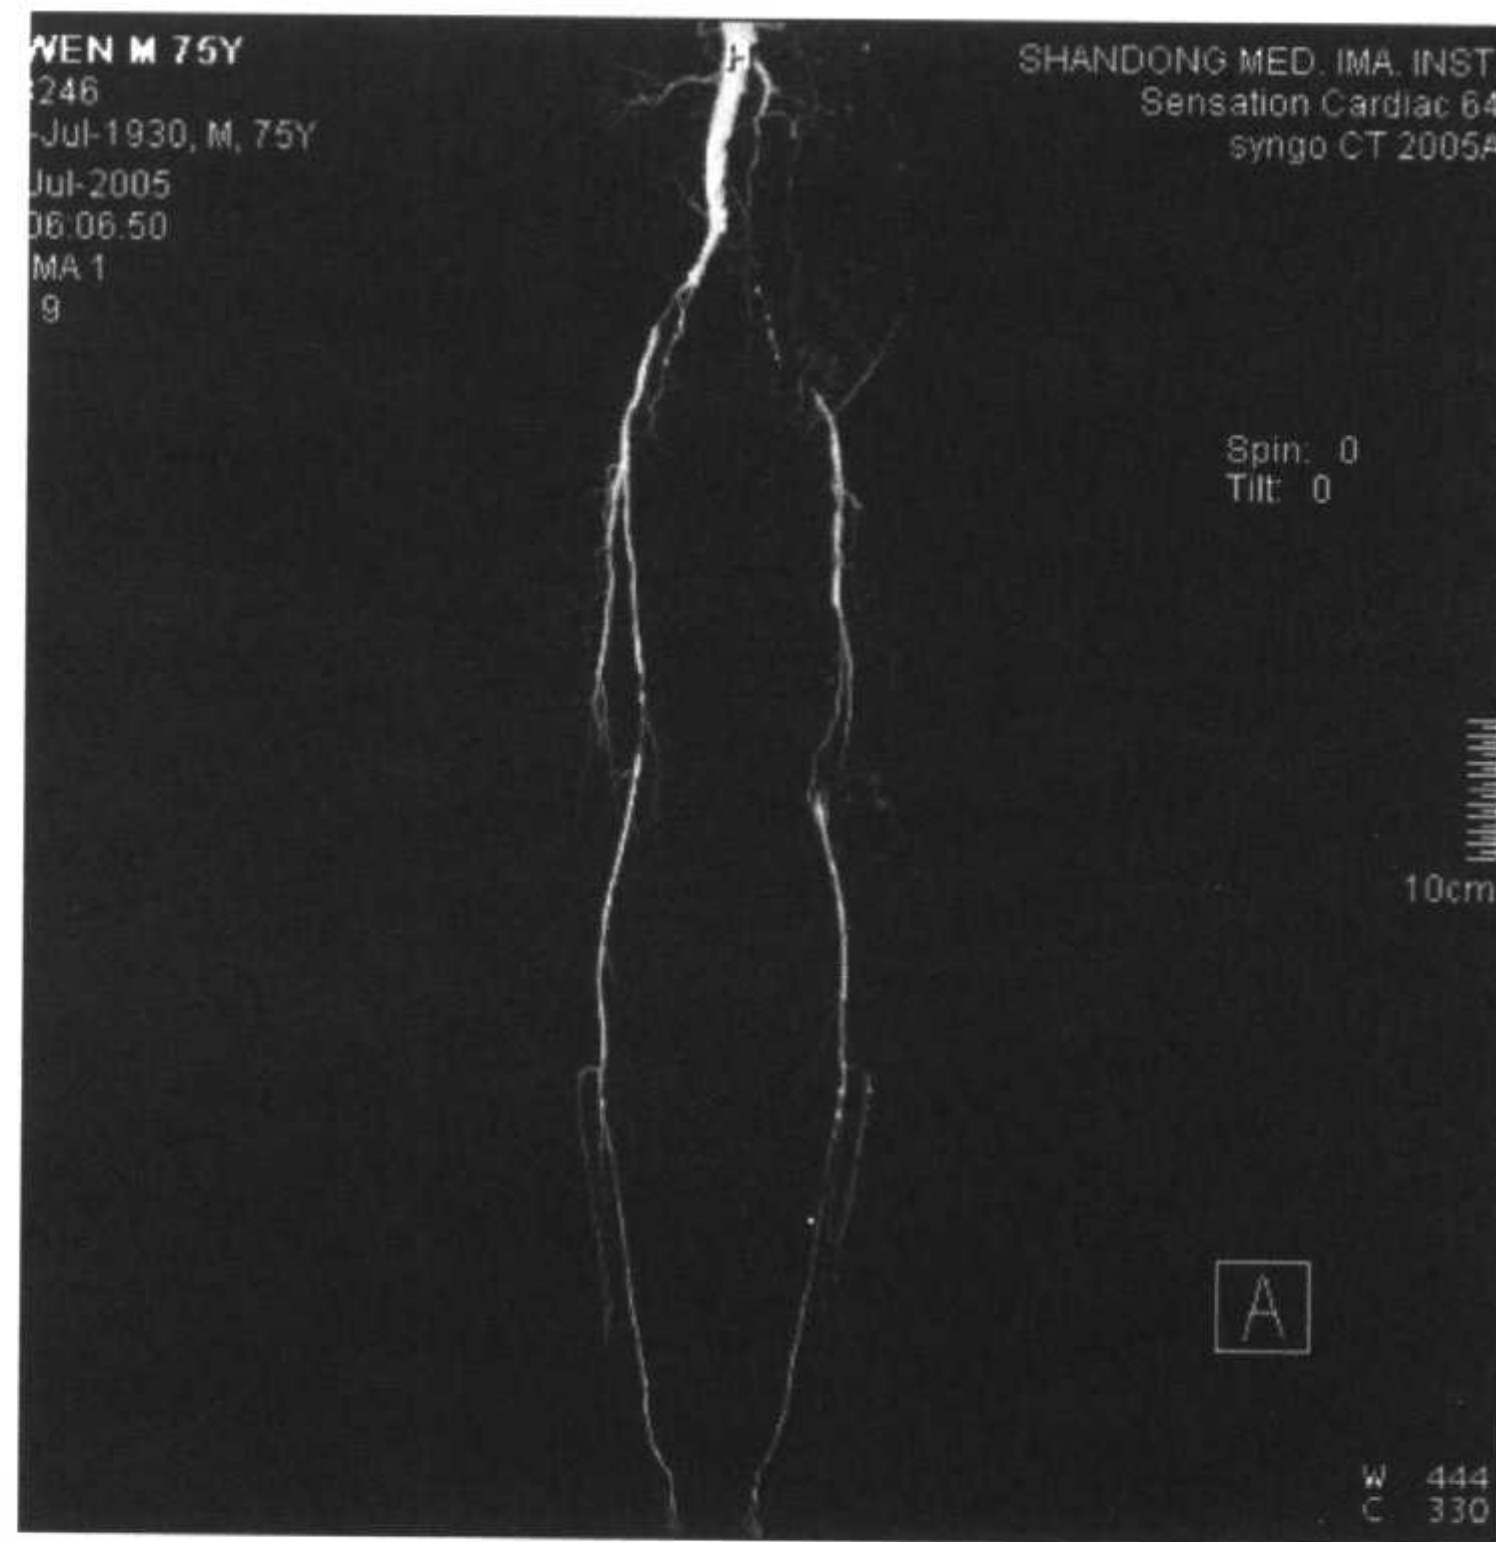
下肢动脉 CTA 及 MIP 重建
